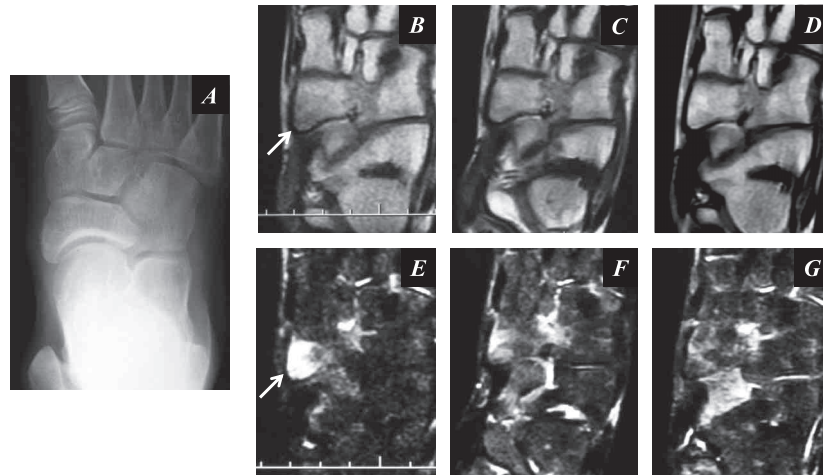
For case 4, no accessory navicular bone is detected on the radiograph (A). T1-weighted (B, C and D) and T2-weighted fat saturated (E, F and G) horizontal MR images at the initial (B and E), after 2 months (C and F) and after 8 months (D and G) demonstrate the gradual diminution in the edema-like bone marrow pattern with alleviation of the symptom.
